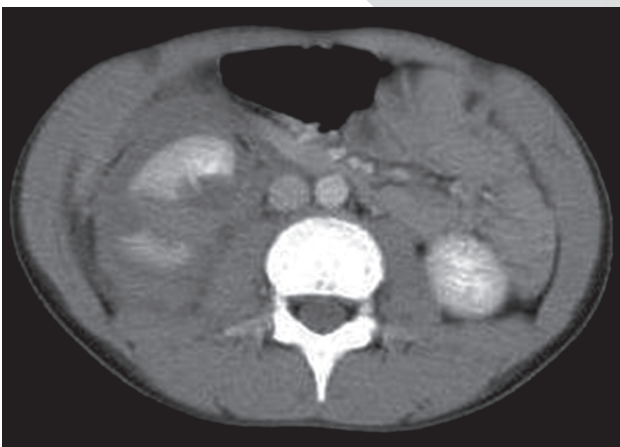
Axial enhanced CT image shows grade 4 renal laceration.
